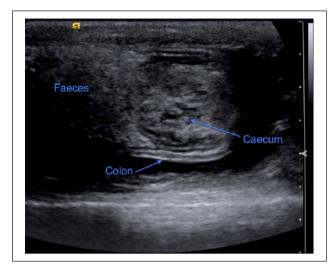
Longitudinal ultrasound image of the caecocolic intussusception. On the left the ascending colon is seen. The small intestine cannot be visualised in this image
